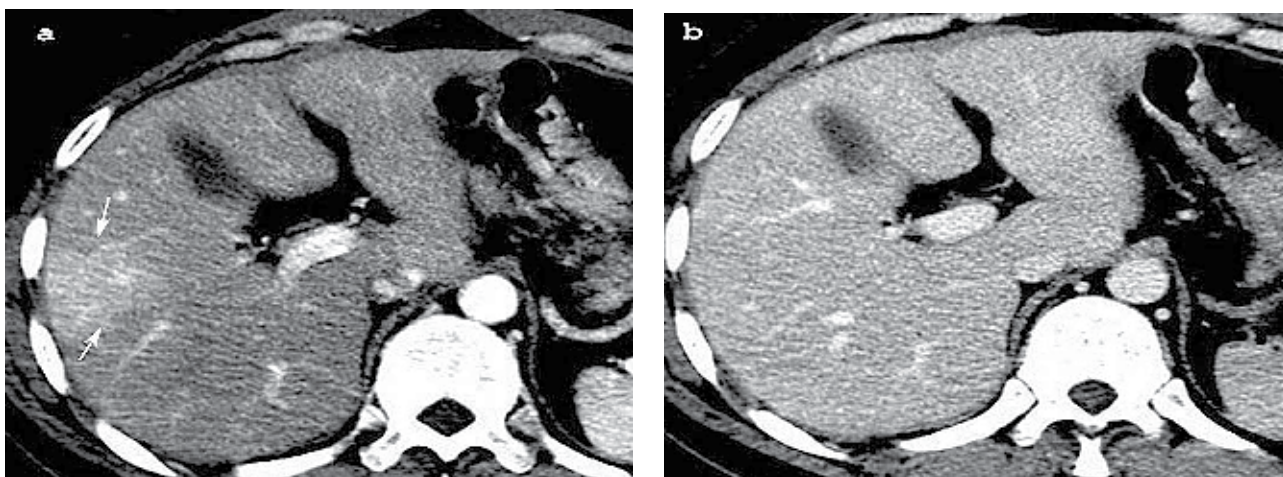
Transient hepatic parenchymal enhancement (THPE) post iatrogenic arterio-portal shunt. (a)-arterial helical CT and (b) portal venous phase; triangular hyperattenuating area (long arrows) on enhanced hepatic arterial phase with normal aspect on portal phase.
